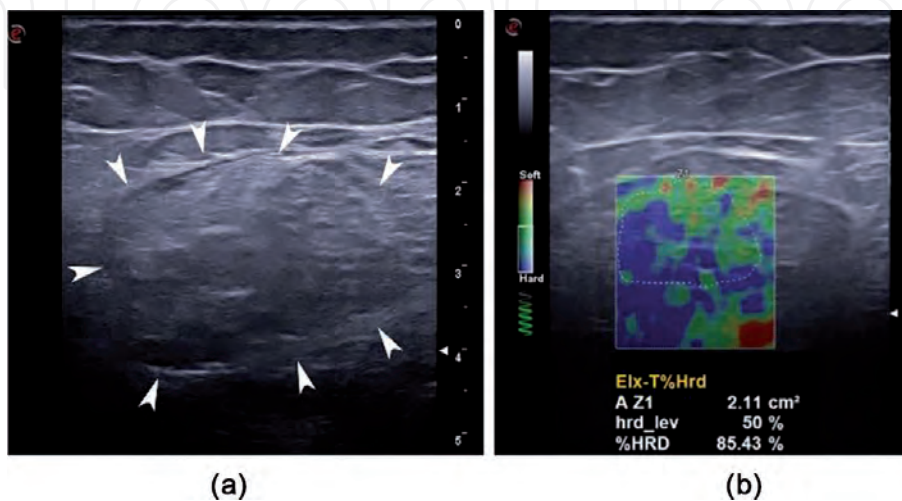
Ultrasonography of the rectus femoris in a patient with polymyositis, that shows increased echogenicity and lack of the starry night appearance in GS mode (a), and decreased elasticity as showed by the blue color in elastography and the hardness percent (b).
